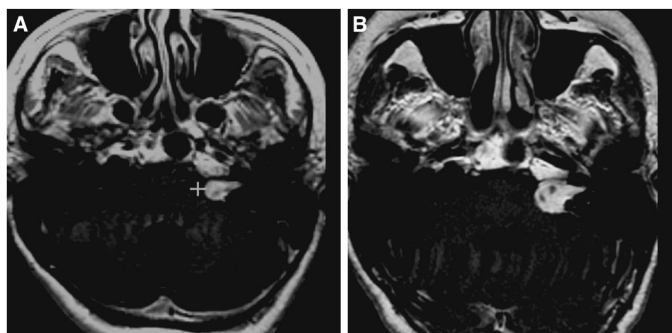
Magnetic resonance imaging (MRI) of 51-year-old woman with a recurrent vestibular schwannoma demonstrating type 1 pattern after radiosurgery. A, MRI at time of radiosurgery. B, MRI 5 months after radiosurgery showing increase in tumor volume and loss of central enhancement. C, MRI 71 months after radiosurgery showing tumor decreased in size compared to radiosurgery.
